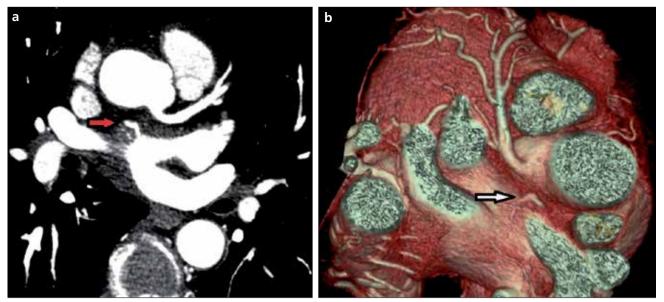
a, b. Axial CT image (a) and three-dimensional reconstruction (b) demonstrate a lobulated atrial diverticulum (arrows).
